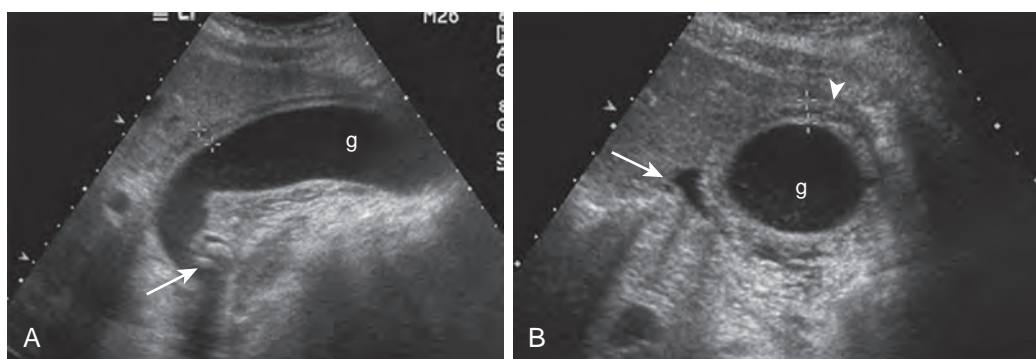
Acute cholecystitis: ultrasound. A. Sagittal scan demonstrates gallbladder distention (g) and wall thickening (calipers). Arrow, Stones in gallbladder neck. B. Transverse scan of gallbladder (g) demonstrates wall thickening (arrowhead) and pericholecystic fluid (arrow). A sonographic Murphy sign was demonstrated.
